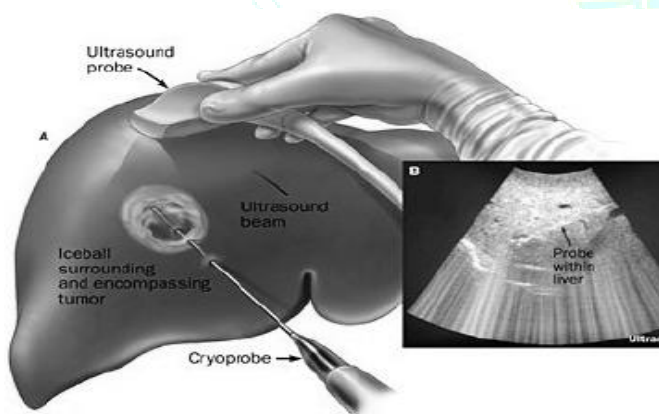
Cryosurgery of hepatocellular hematoma; B, corresponding ultrasound showing the probe in the tumor.
